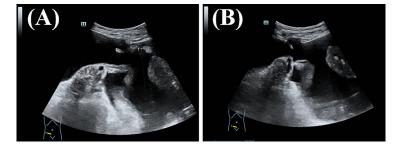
Postoperative imaging. (A) Ultrasound imaging showing massive ascites. (B) Puncture and drainage in the surgical area performed under the guidance of ultrasound.
